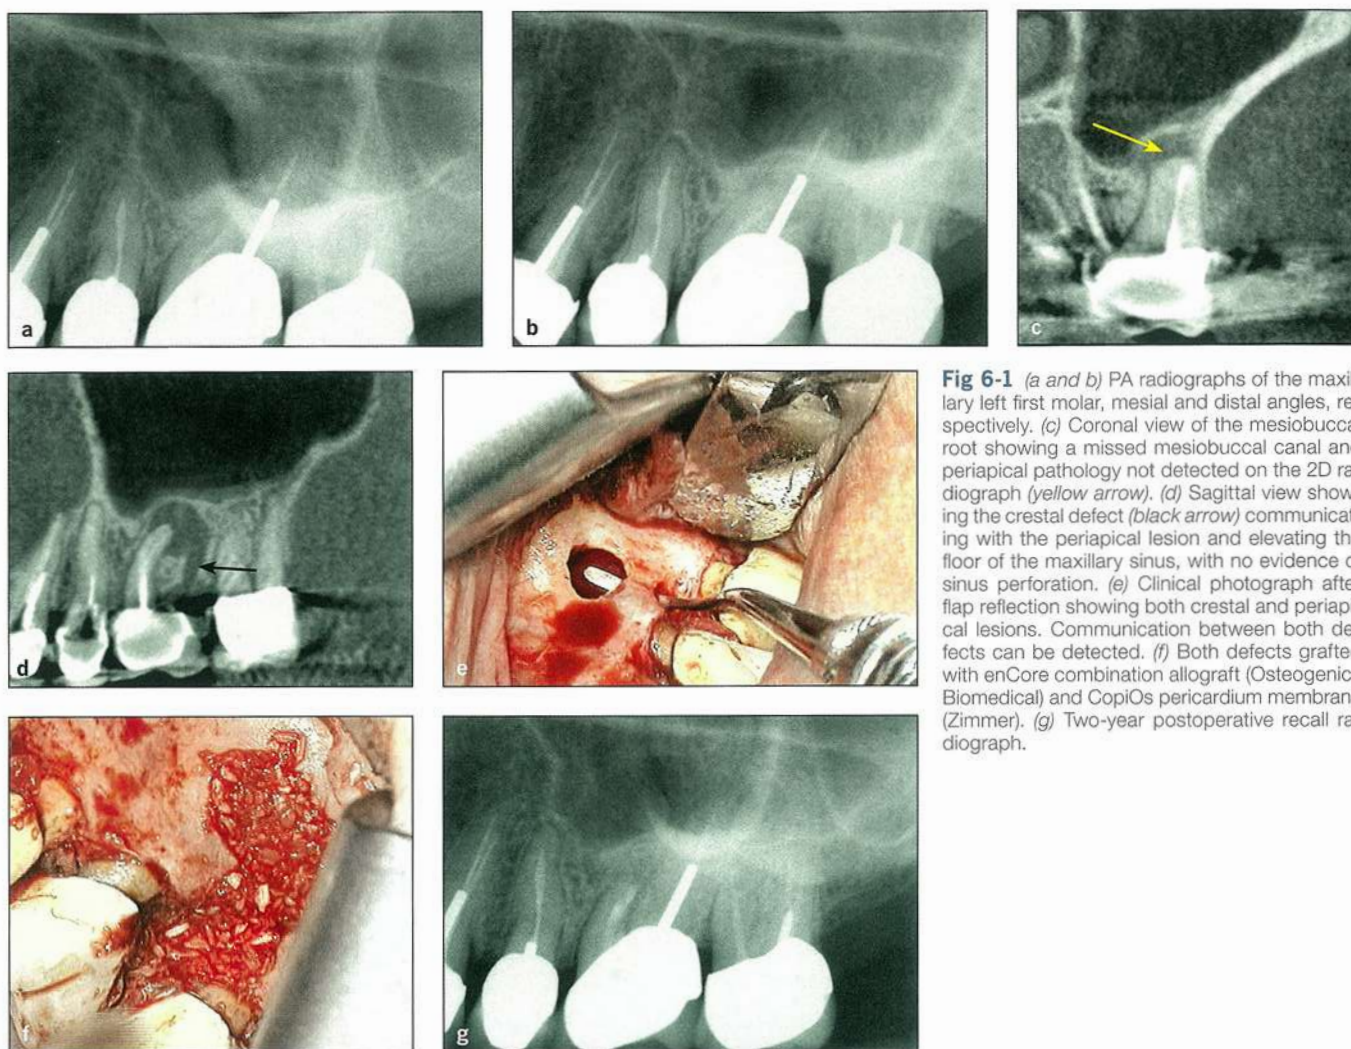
(a and b) PA radiographs of the maxillary left first molar, mesial and distal angles, respectively. (c) Coronal view of the mesiobuccal root showing a missed mesiobuccal canal and periapical pathology not detected on the 2D radiograph (yellow arrow). (d) Sagittal view showing the crestal defect (black arrow) communicating with the periapical lesion and elevating the floor of the maxillary sinus, with no evidence of sinus perforation. (e) Clinical photograph after flap reflection showing both crestal and periapical lesions. Communication between both defects can be detected. (f) Both defects grafted with enCore combination allograft (Osteogenics Biomedical) and CopiOs pericardium membrane (Zimmer). (g) Two-year postoperative recall radiograph.
